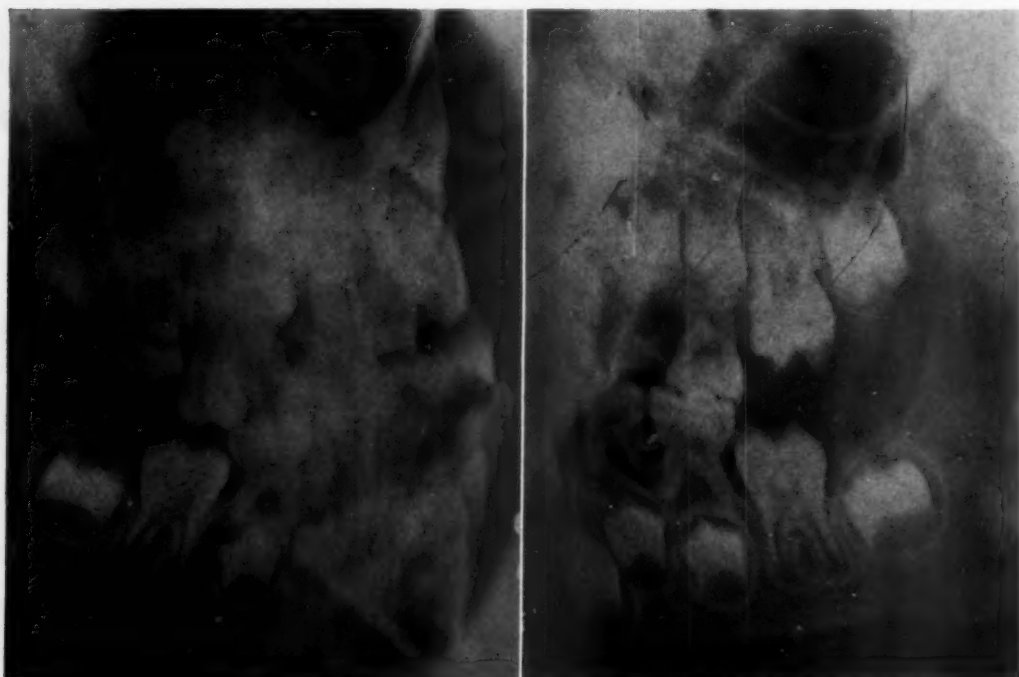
Lateral jaw roentgenograms showing noneruption of the permanent first molars, although general dental development shows progress following thyroid therapy.
